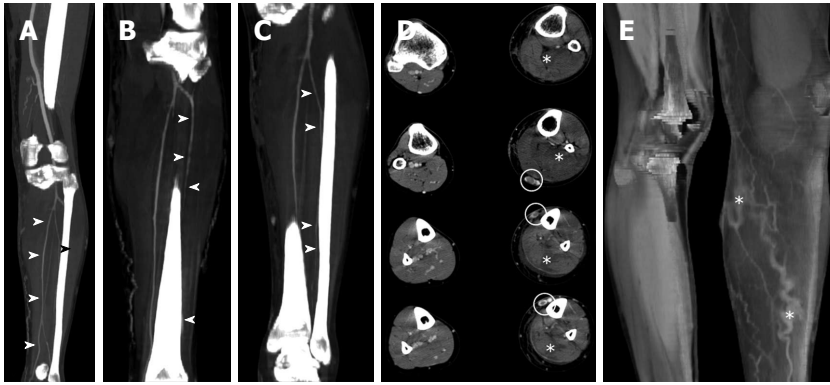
A computed tomography of the lower leg revealed a swollen compartment without vascular lesions and hypertension at the venous end of the capillary beds. A, B, C: The reconstruction MIP/3D that showed the viability of posterior tibial (A), anterior tibial (B) and interosseal artery (C) (marked by headarrows); D: The swollen muscle compartment (marked by *); E: The presence of hypertension at the venous end of the capillary beds (marked by *).
